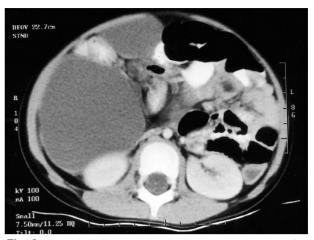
Abdominal CT scan showing a large cystic mass with septa displacing the bowel loops.
